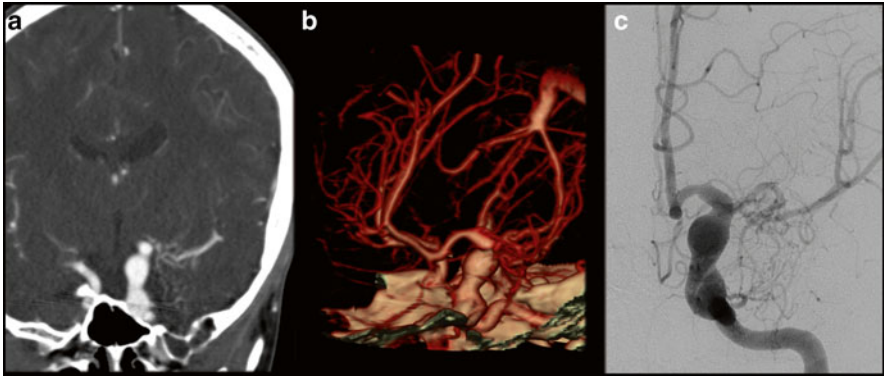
A 14-year-old boy presented with non-related symptoms. As an incidental finding ectasia of the carotid artery was found and CTA was ordered. MIP images from the CTA (a), volume rendering (b), and DSA (c) show fusiform dilatation of the intradural segment of the carotid artery and proximal A1 segment
